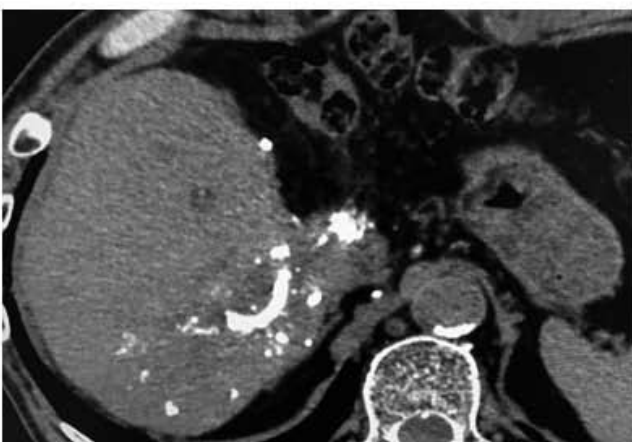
The follow-up computed tomography revealed occlusion of the B7-posterior biliary branch without abscess formation in the liver or intra-abdominal 8 months after the embolization.
